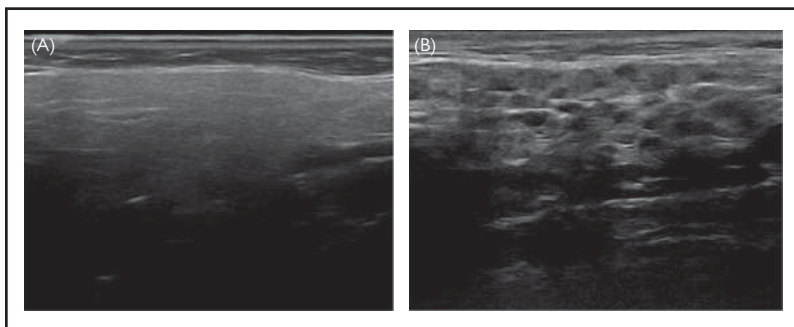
(A) Ultrasound image of a healthy parotid gland. (B) Ultrasound image of the parotid gland of a patient with Sjögren's syndrome showing the characteristic 'pepper-and-salt appearance'.
